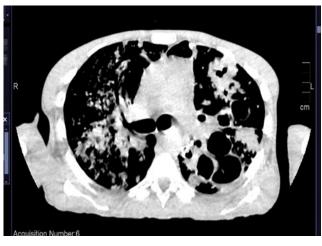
Chest CT parenchymal window showing multiple cavities and mediastinal adenopathy.
